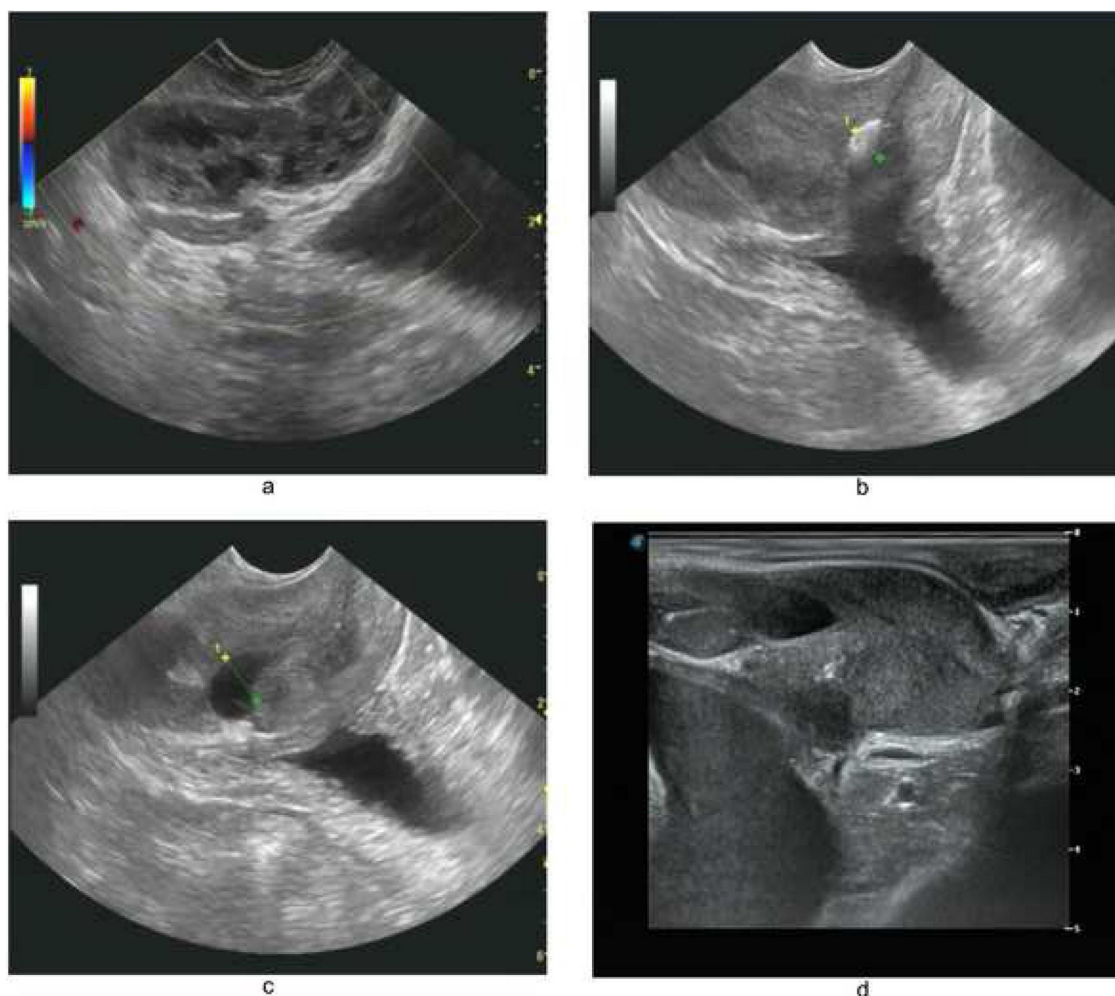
Transrectal ultrasound findings in acquired obstructive azoospermia, (a) chronic seminal vesicle inflammation, (b) ejaculation duct stone or calcification, (c and d) prostate midline cyst.
